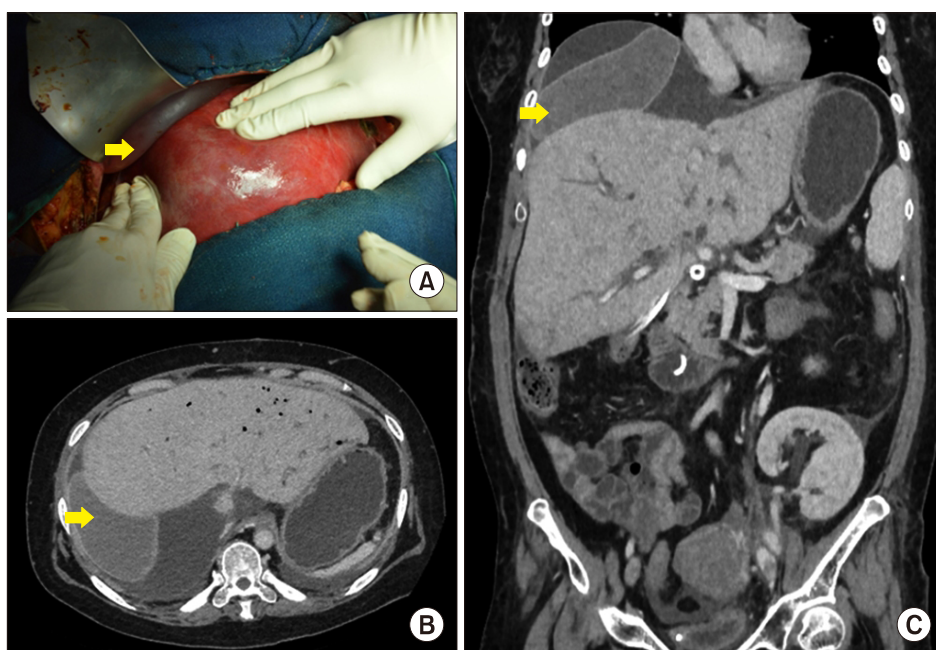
(A) Intraoperative view after placement of a single breast implant (yellow arrow) between the diaphragm and the graft. (B and C) Computed tomography (CT) scans were taken after liver transplantation.
